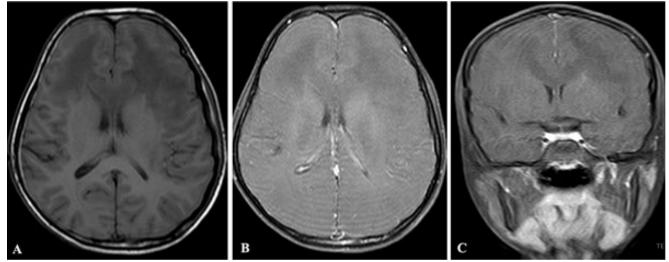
MRI images (A-Axial non-contrast T1 weighted image, B-Axial post contrast T1 weighted image, and C-Coronal post-contrast image) showing no enhancement in the lesion.
